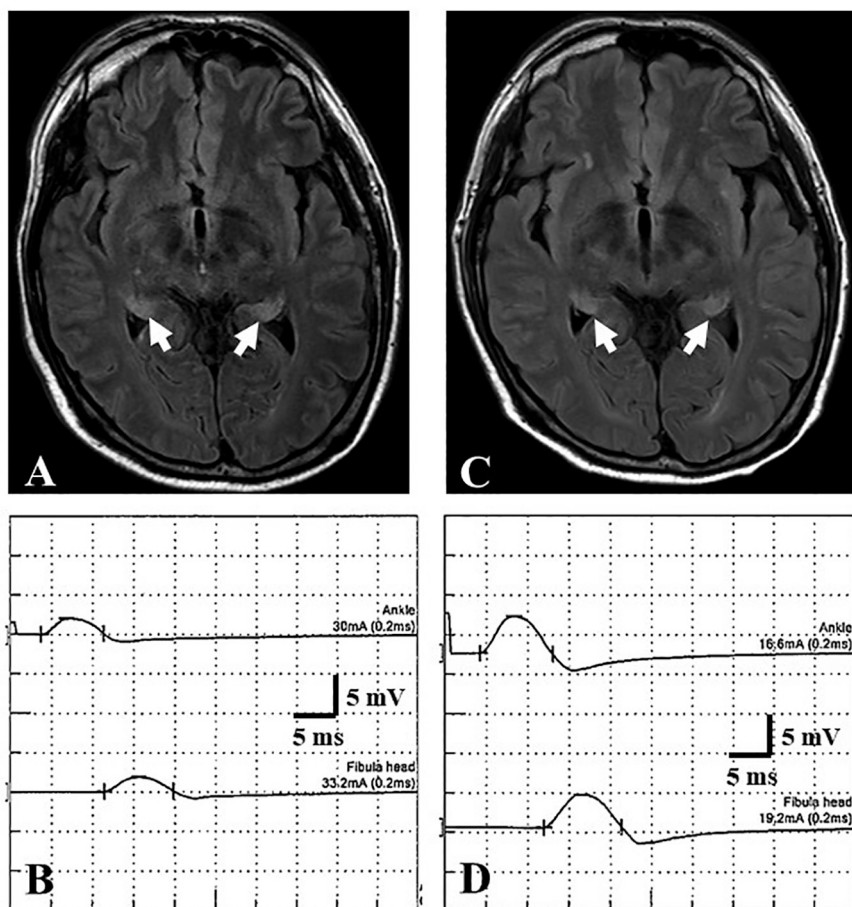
Head MRI (A, C) and nerve conduction studies (B, D).
